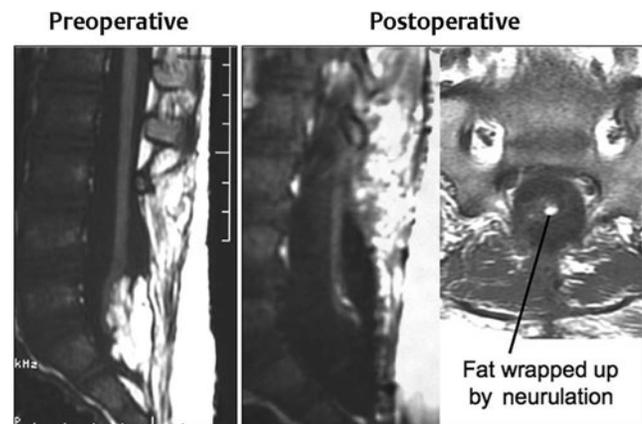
Pre- and postoperative magnetic resonance images of a case of complex transitional lipoma with a very small amount (<20 mm³) of residual fat after resection. Axial image shows the small round piece of fat wrapped up within the roundly neurulated neural placode and therefore not exposed on the surface.
